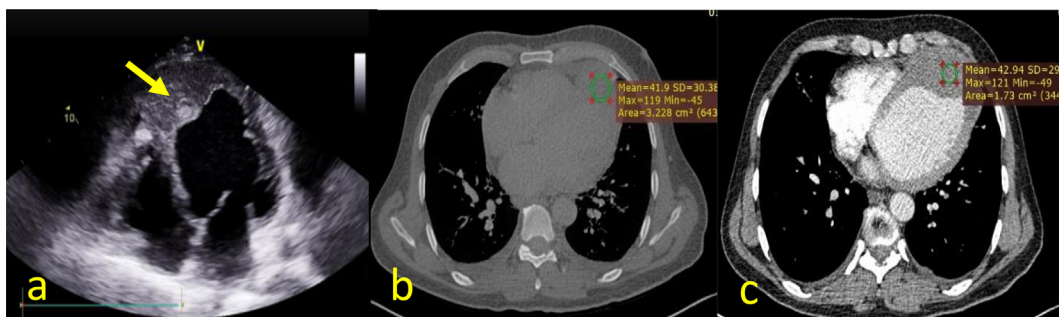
(a): Transthoracic 2D echocardiogram; (b, c): CT scan without (b) and with (c) injection: a. Hyper-echoic image facing the tip of the left ventricle (LV) (yellow arrow). b, c: A spontaneous hyperdense formation Non-enhanced after contrast injection associated with a bilateral pericardial and pleural effusion blade.
